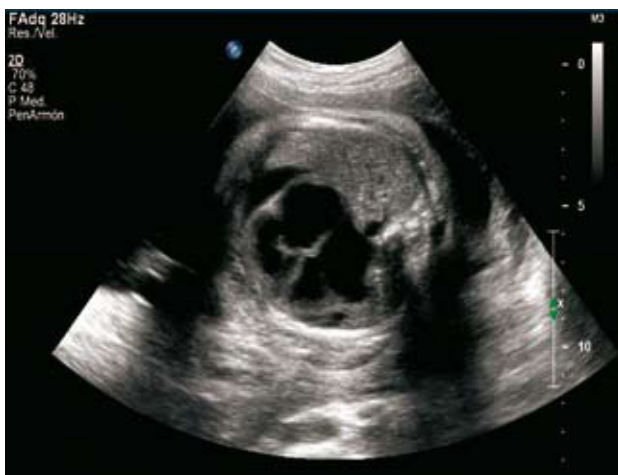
Prenatal echocardiography with pericardial effusion.
